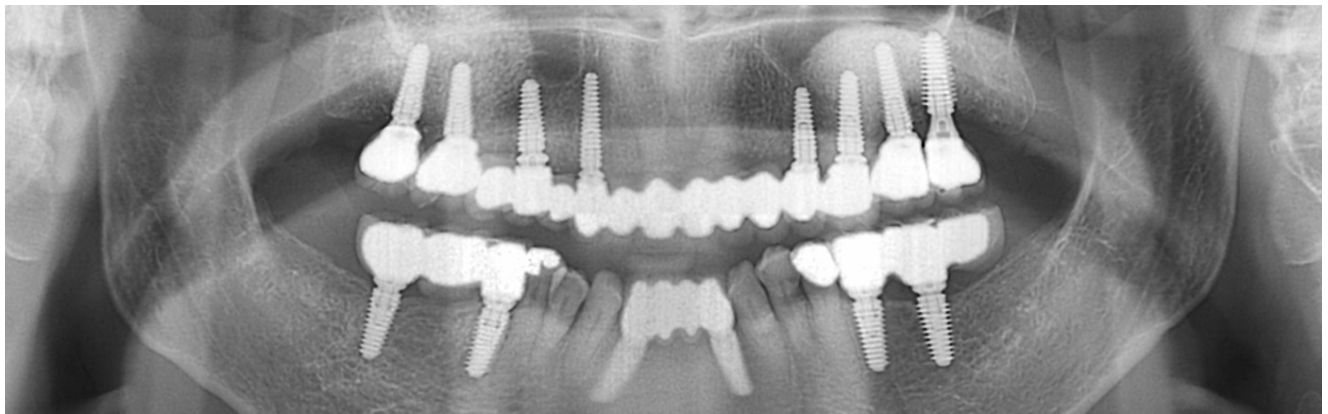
Follow up panoramic X-ray after 3 years, showing successful rehabilitation
